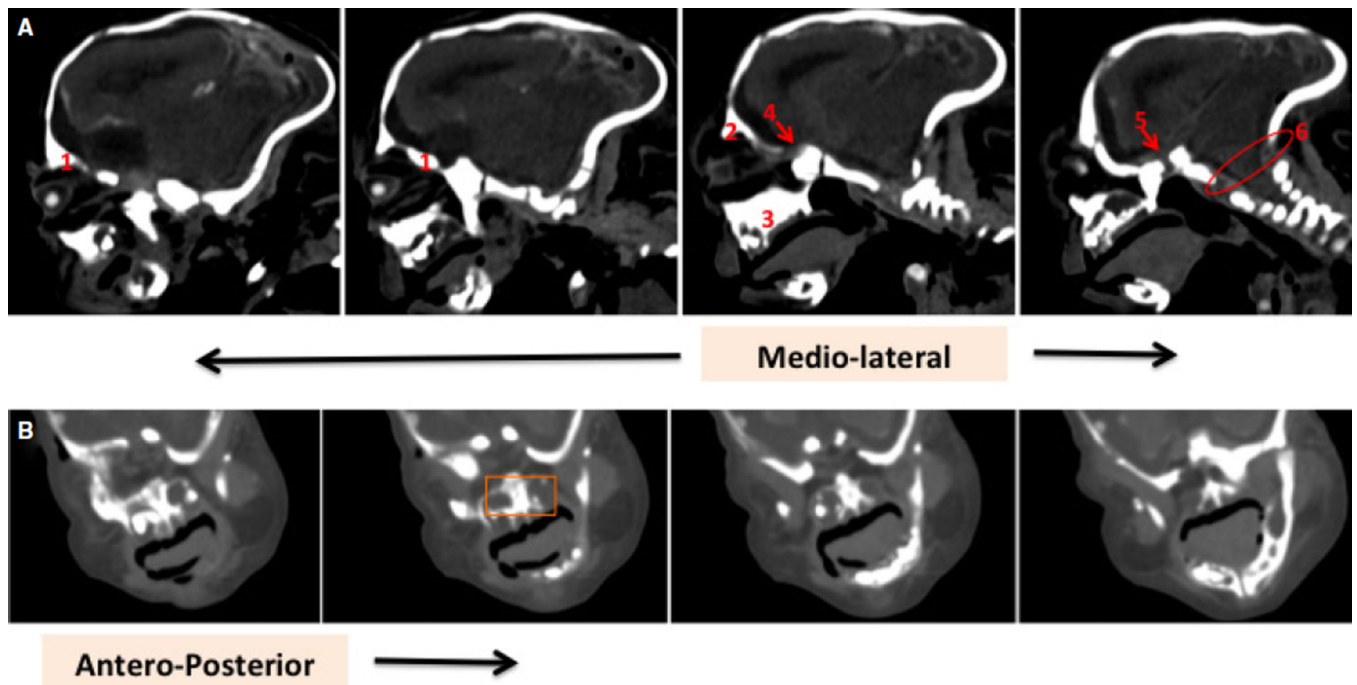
Single CT slice analysis of facial features of the non *aCh18* cyclopia perfecta fetus at 35 weeks. (A) Adjacent mediolateral sections to emphasize the presence of the (1) orbital plate of frontal bone, (2) frontal process, (3) nasal septum, (4) centrally located optic nerve, (5) pituitary (appears gray surrounded by white sella turcica of the body of the sphenoid) and (6) enlarged foramen magnum. (B) Anteroposterior sections are shown to emphasize centrally located nasal structures, including radiodense septum/conchae, and radiolucent maxillary sinuses on either end.
